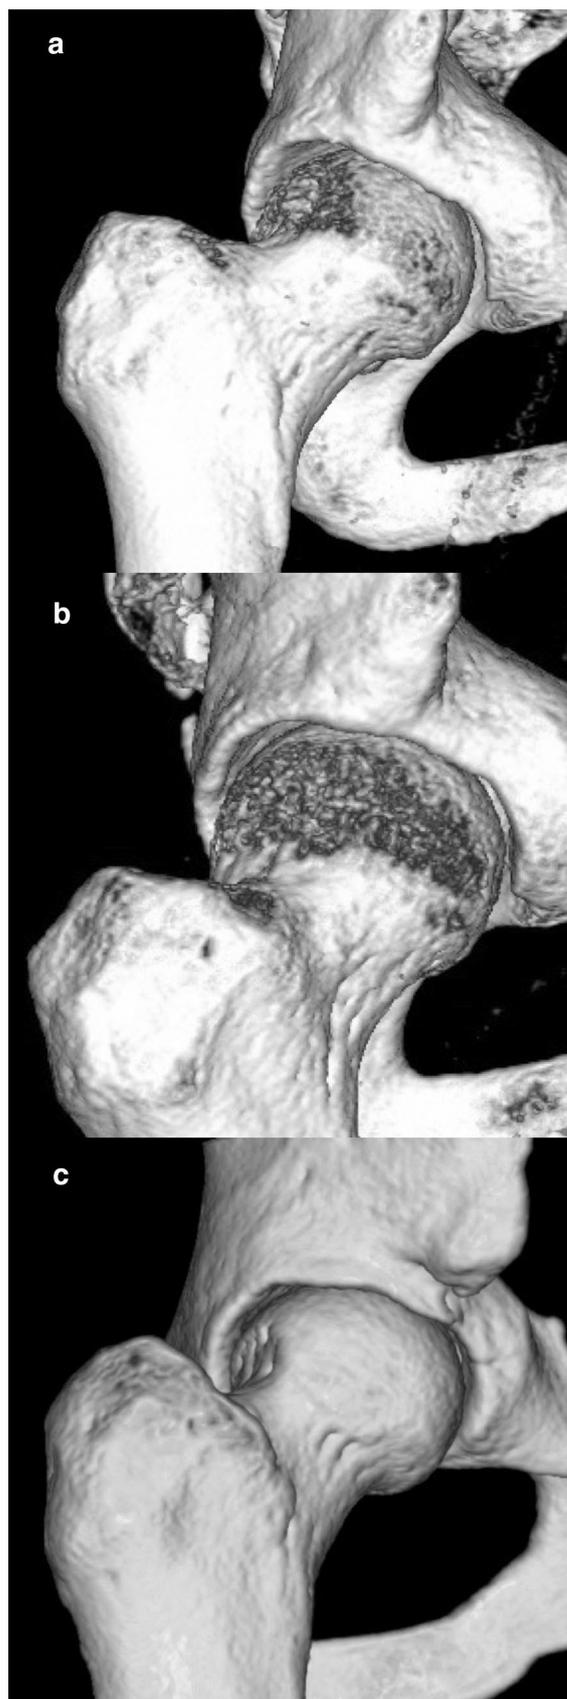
CT scan of Type I variant of the AIIS—defined as a smooth ilium wall between the caudal level of the AIIS and the acetabular rim
